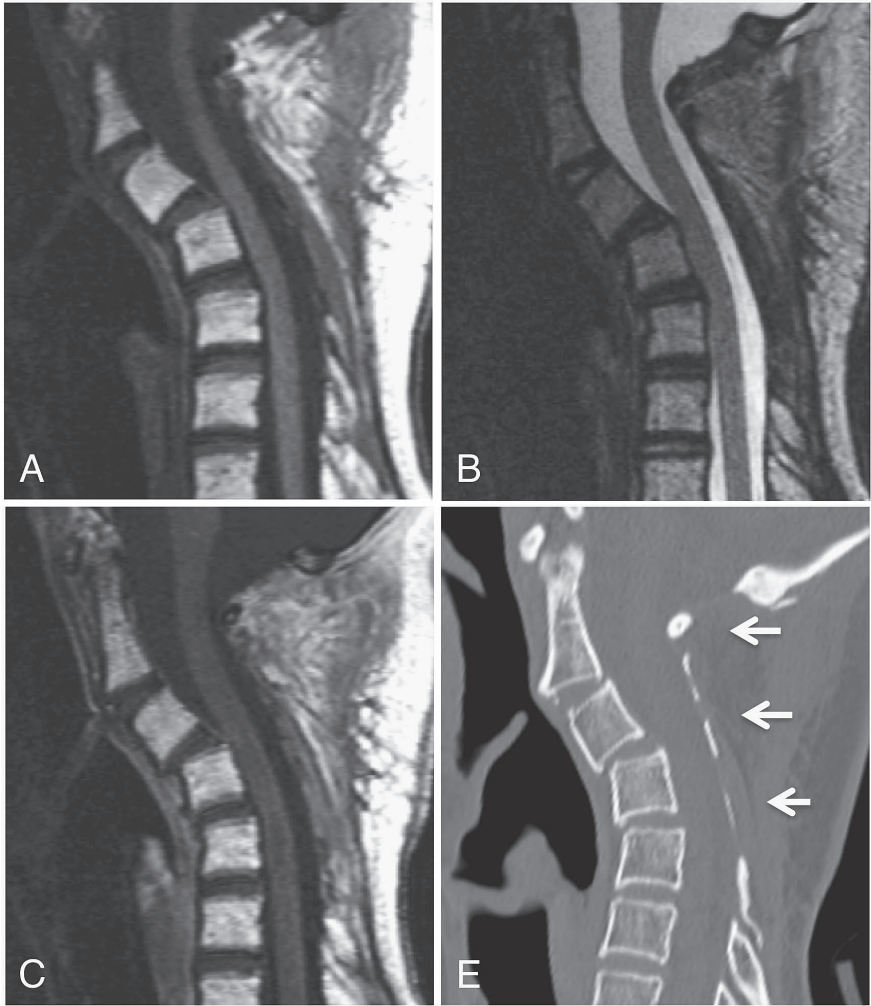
MRI and CT of the cervical spine after radiation. Cervical kyphotic change was seen in C2-5. The involved vertebral bodies, laminae, and spinous processes showed homogeneous high signal intensity on both T1- and T2-weighted images (A, B). There were no significant enhanced lesions on Gd-DTPA (C). On CT, the cortical bone was clearly visualized, and the small radiolucent foci disappeared (arrows) (E).
